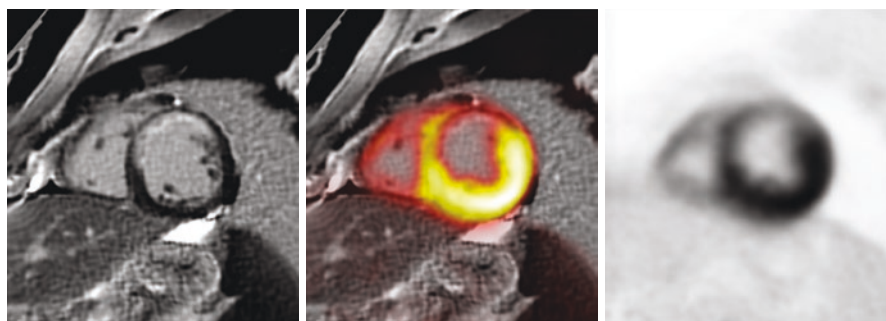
FDG PET/MRI for viability imaging. A 63-year old man was referred to our institution for FDG PET/MRI viability imaging for a known chronic total occlusion of the left anterior descending artery (LAD). Late gadolinium enhancement (LGE) MRI depicts a transmural scar of the anterior wall (left panel). FDG PET shows a well-matched reduction of FDG uptake in the identical region (right and middle panel). Also, a severe wall motion abnormality was observed in this area. Taken together these images demonstrate that myocardium is non-viable in the LAD territory
